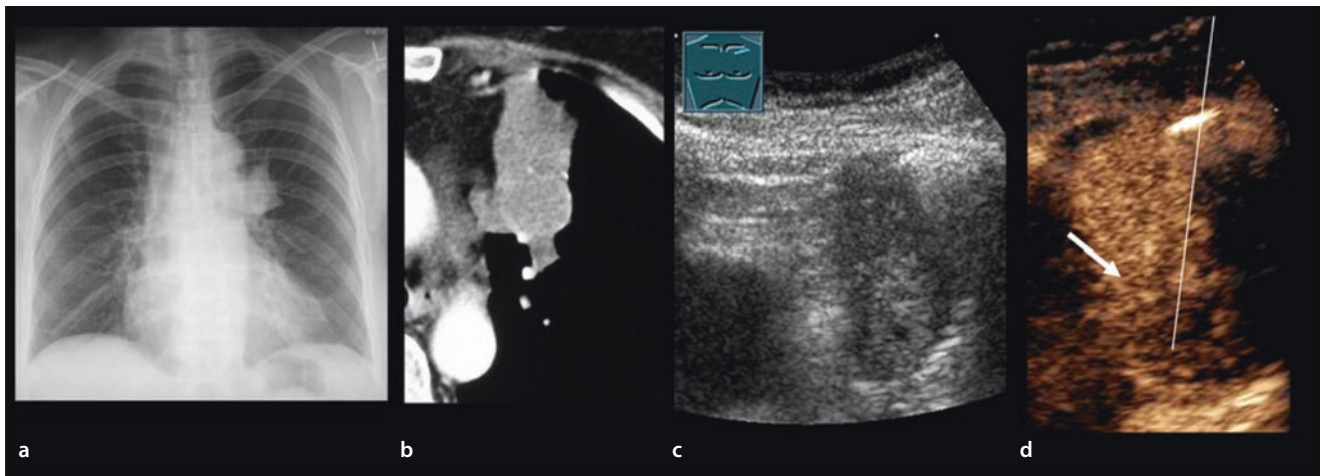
Man with bronchial carcinoma. a The chest X-ray shows a space-occupying lesion in the left-sided hilum. b CT reveals a central tumor formation touching the chest wall. The tumor could not be seen on bronchoscopy. c Through a narrow “window”, B-mode ultrasonography shows an inhomogeneous space-occupying lesion
